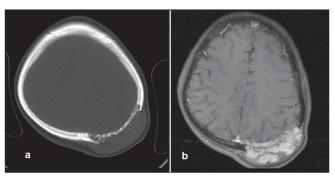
(a) Computed tomography axial section showing a destructive osteolytic lesion of the parietal bone with destruction of the outer table with a soft tissue mass overlying the defect, (b) Magnetic resonance imaging showing well defined intradiploic contrast enhancing mass in the parietal bone with extension into the occipital bone
